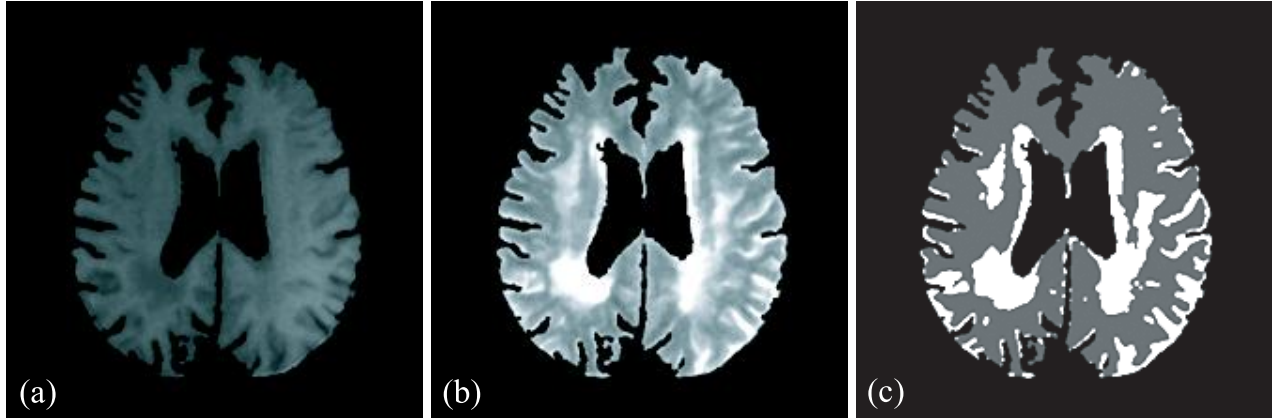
The effect of our leukoaraiosis detection method based on clustering technique. (a) Segmented cerebral region in the T1-weighted image. (b) Segmented cerebral regions in the T2-weighted image. (c) Result image of clustering technique. The white regions are the candidate regions obtained by the clustering technique. Almost all leukoaraiosis regions were detected accurately.
